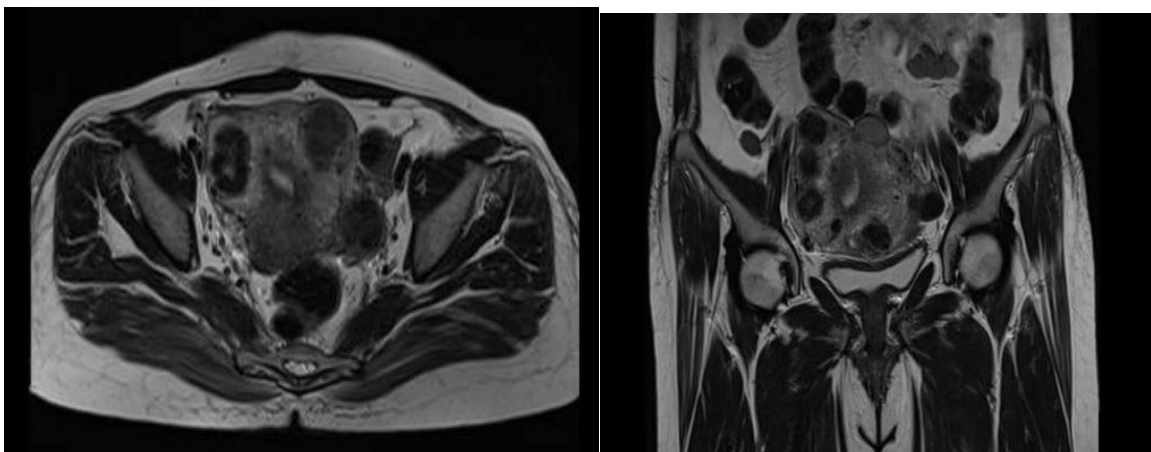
Multiple myomas as incidental findings in lumbosacral MRI in a patient with doubt to discopathy.
